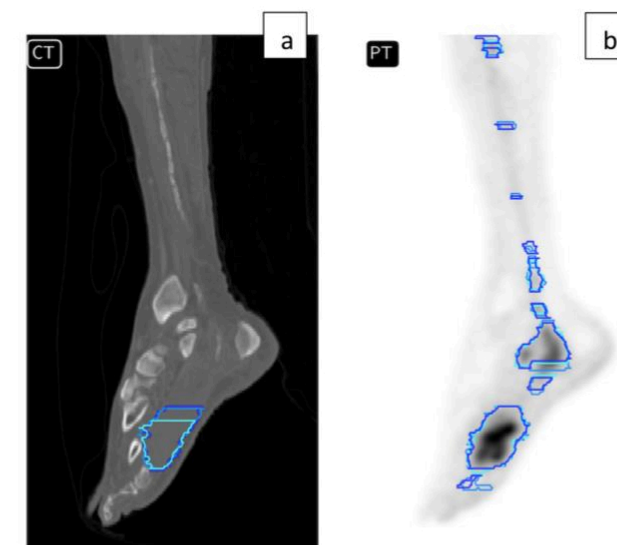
Sagittal view of GTV contours drawn using CT alone (a) and using CT, MR, and PET (b). Distant spread from a primary tumor in the foot is only seen on PET.
